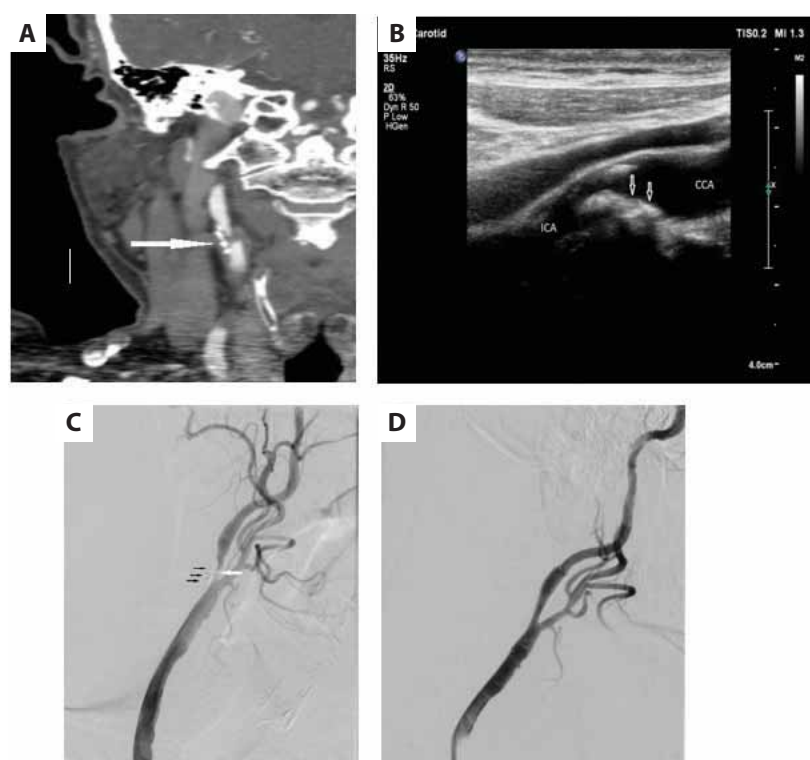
Calcified plaque-causing severe stenosis in the internal carotid artery (arrow). B-mode sonography (A), computed tomography angiography (B), and digital subtraction angiography before stenting (C), after stenting (D)
